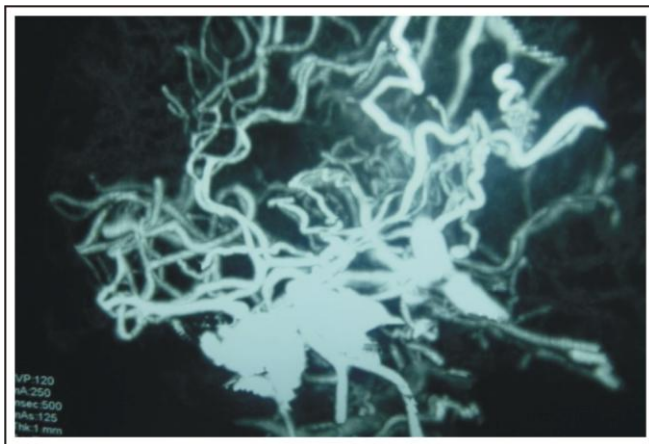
CT angiography brain showing dilated cavernous sinuses due to carotid cavernous fistula.
